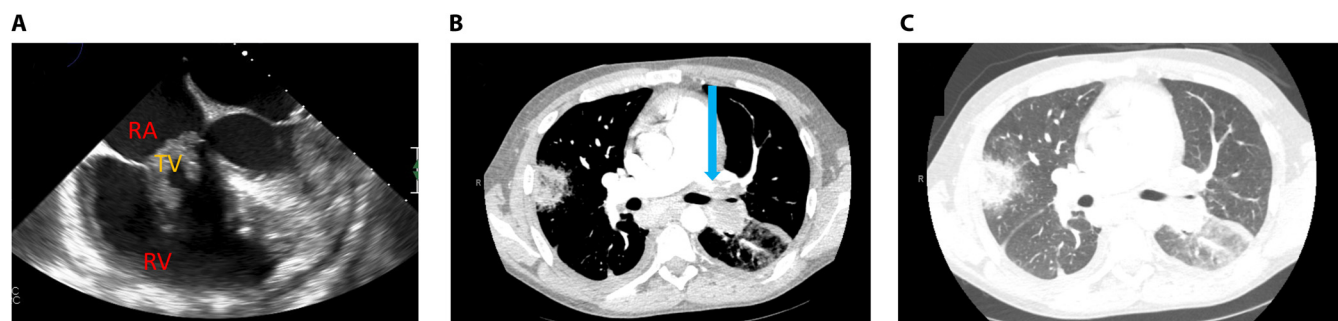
Tricuspid valve endocarditis caused by *A. fumigatus*. (A) Off-axis, 4-chamber view of large tricuspid valve (TV) vegetation on transesophageal echocardiogram (right atrium, RA; right ventricle, RV). (B) Left pulmonary artery embolus (blue arrow). (C) Peripheral consolidative opacity from emboli.
